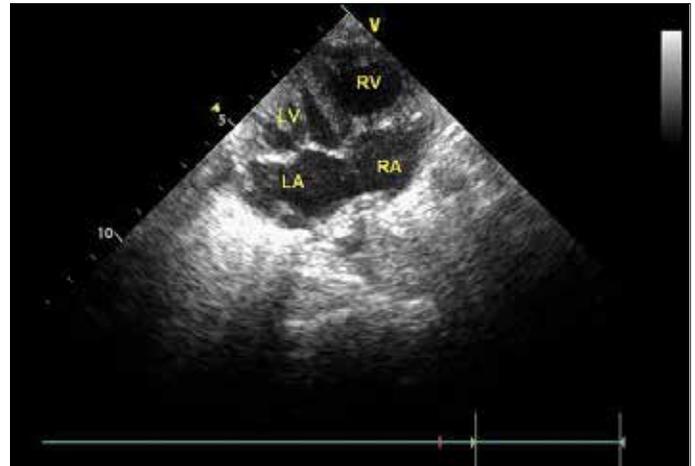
Echocardiogram showing a four-chambered heart with two ventricles and two atria
